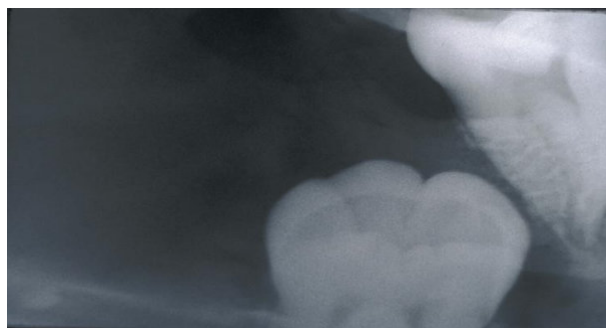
Periapical radiograph showing tooth #38 displaced towards the mandibular basal bone due to an osteolytic radiolucent lesion.
